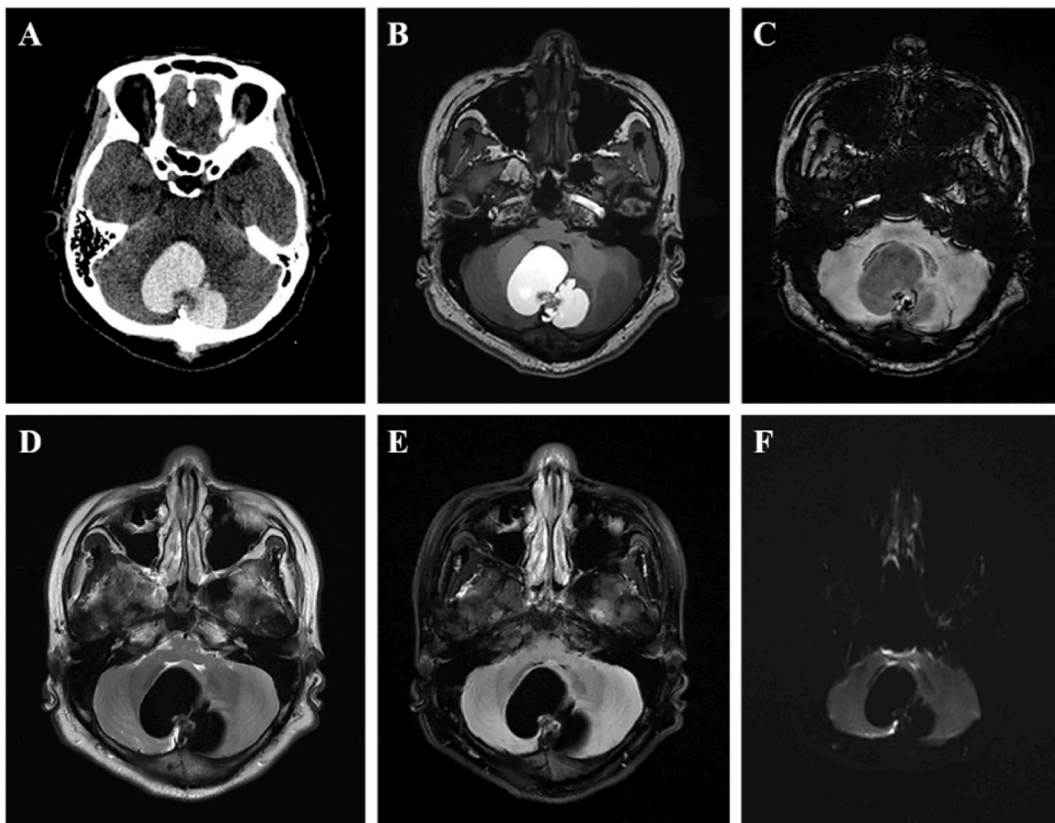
Axial CT showed as follows: Irregular high-density mass shadows in the posterior fossa, with a CT value of about 93HU; few bones density shadows visible at the posterior edge, with the compression of adjacent bilateral cerebellar hemispheres and brainstem, and narrowing of the fourth ventricle (A). MR imaging showed irregular mixed signals distributed across the midline in the medial and posterior cerebellum, with a maximum diameter of about 50 mm × 41 mm × 51 mm. Line-like septum and complex nodules with a slightly irregular shape were visible inside the cyst, with the nodule size of about 15 mm × 16 mm × 13 mm (maximum oblique diameter). The brain parenchyma around the lesion was compressed, with slight narrowing of the fourth ventricle. T1WI (B) of the cystic part was mainly equal or high signals. T2WI (D) and T2 flair (E) both showed low signals. DWI sequence (F) showed low signals, with no diffusion restriction in mural nodules and septum; multiple patchy low signals and high signals were visible in the nodular of SWI sequence (C).
